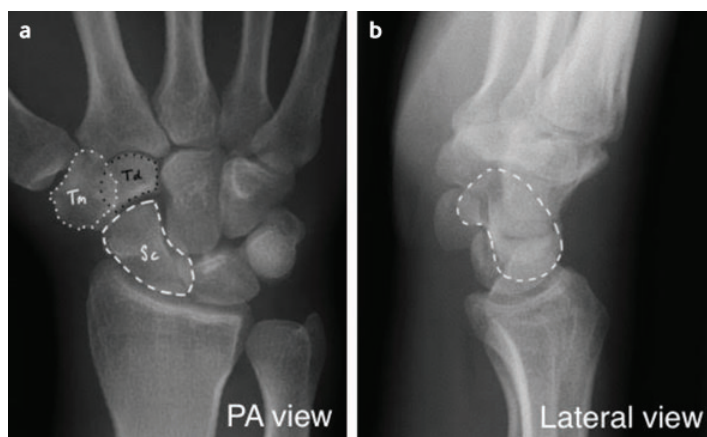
Initial radiographs obtained in the emergency department with and without labels. These only included standard (a) posteroanterior and (b) lateral views of the wrist. No scaphoid fracture was visible on these views. Scaphoid (Sc) marked with a broken white line; trapezium (Tm) marked with dotted white line, and trapezoid (Td) marked with dotted black line
